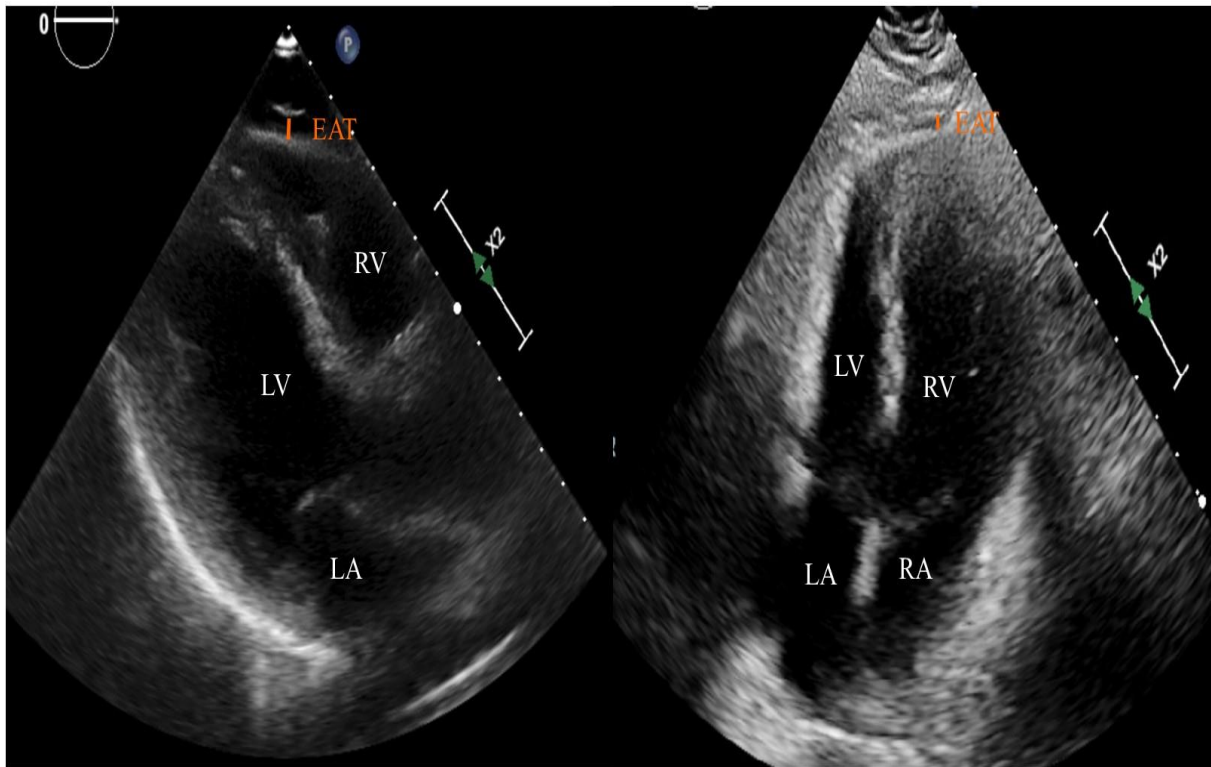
Echocardiographic measurements of epicardial adipose tissue thickness on the right ventricular free wall and in the area of anterior interventricular groove. Abbreviations: EAT – epicardial adipose tissue, LA – left atrium, LV – left ventricle, RA – right atrium, RV – right ventricle
